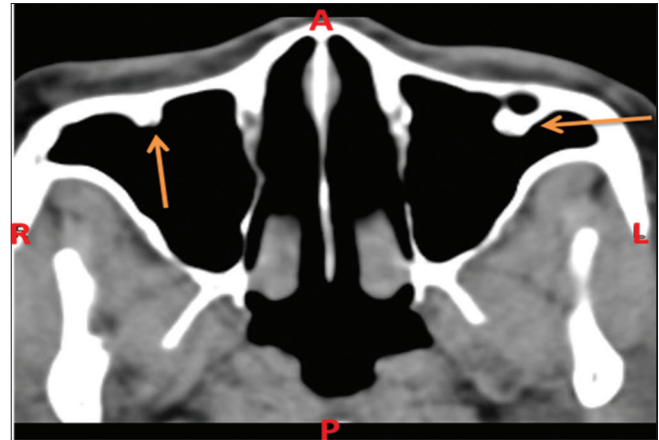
Axial computerized tomography (CT) of a 45-year-old male showing arrows pointing toward septa on the anterior and anterolateral sinus walls. A = anterior, P = posterior, R = right side, L = left side
